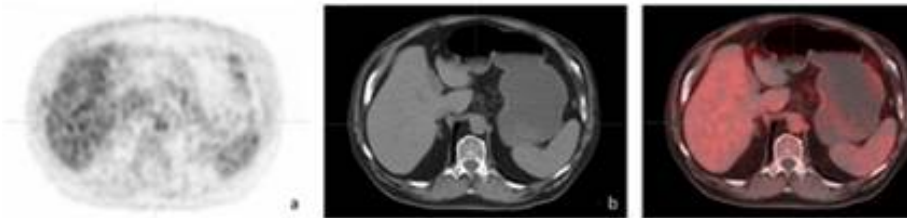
Normal patient. PET and CT are commonly acquired together. Figure 13a. PET allows evaluation of metabolic activity, but tends to have poor resolution. Figure 13b. CT has high spatial resolution. Figure 13c. Merging PET and CT allows for more accurate evaluation of the anatomical structures and their metabolic activity. University of Massachusetts Medical School, Department of Radiology.
